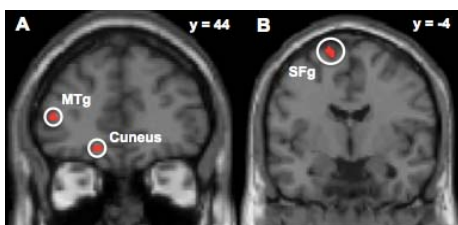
Brain areas showing a significant decrease (A + B) in gray matter after parabolic flight. Data are presented in normalized stereotactic space, overlaid on a high-resolution anatomical MR image with the right side of the brain shown on the left (numerical labels, y coordinates of coronal slices).
